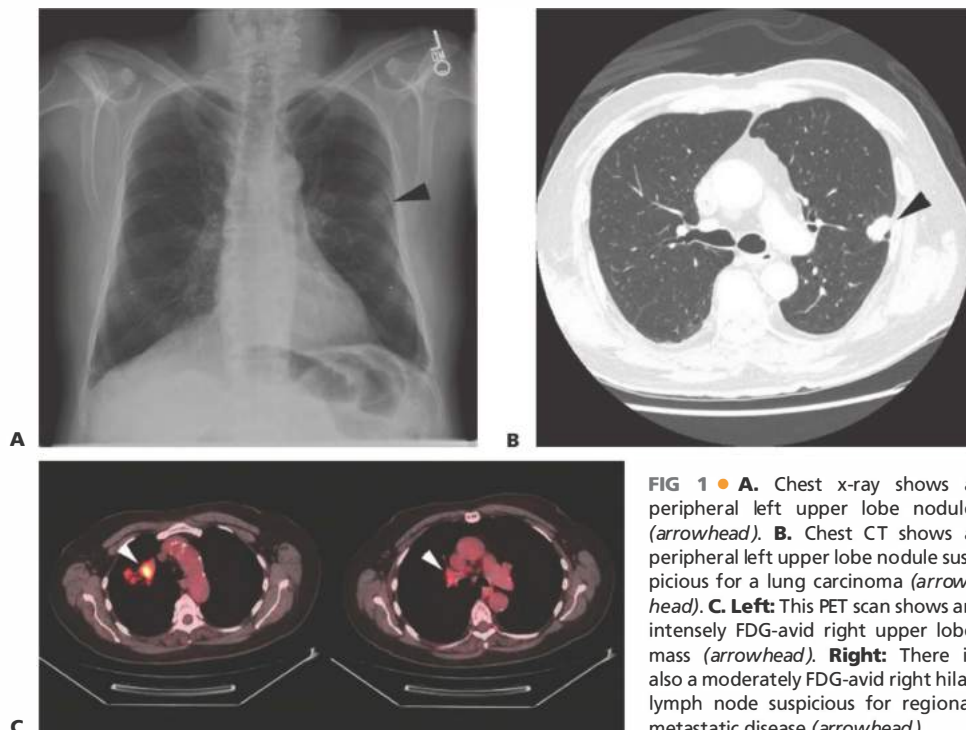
• A. Chest x-ray shows a peripheral left upper lobe nodule (arrowhead). B. Chest CT shows a peripheral left upper lobe nodule suspicious for a lung carcinoma (arrowhead). C. Left: This PET scan shows an intensely FDG-avid right upper lobe mass (arrowhead). Right: There is also a moderately FDG-avid right hilar lymph node suspicious for regional metastatic disease (arrowhead).
